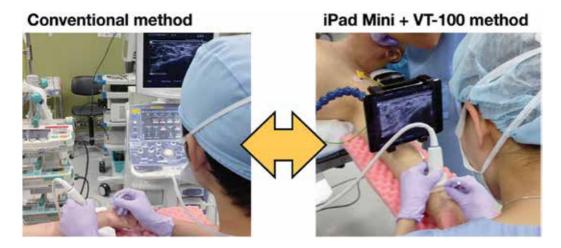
Positional relationships with conventional method and iPad Mini with VT100 method. With the conventional method, the ultrasound machine (ProSound Alpha 7) is placed at the head side of the patient and the puncture operator stands on the caudal side, with the patient forearm between them. With the iPad Mini with VT100 method, the axis running from the eye of the operator to the puncture needle and ultrasound image displayed on the iPad Mini are aligned as closely as possible along a straight line.
